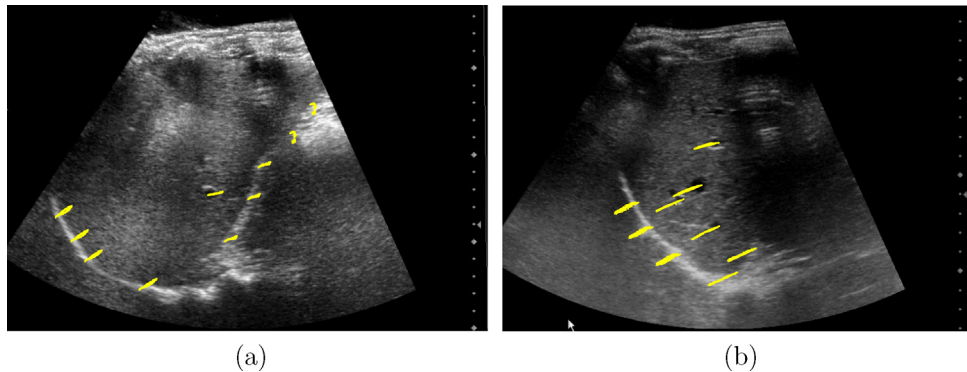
Ultrasound tracking of five cycles for two subjects. (a) tracked points of subject 1 are distributed mainly along the liver surface, as the available acoustic window did not expose many vessel structures inside the organ. (b) trajectories for subject 4 could be extracted at the diaphragm and also for vessels within the liver. The acoustic shadow occluding about half of the liver is a typical artefact due to absorption by the ribs.
